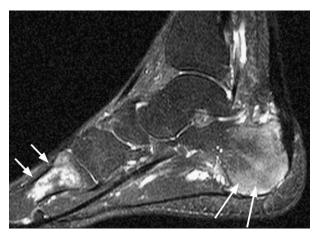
Sagittal T2-weighted fat-suppressed magnetic resonance image of 25-year-old athlete showing concomitant stress injuries in the first metatarsal bone (short arrows) and calcaneus (long arrows). These stress injuries comprise marrow edema alone without a visible fracture line. Note the high medial longitudinal arch, which may have contributed to the stress injuries in this patient. Radiograph was negative.
